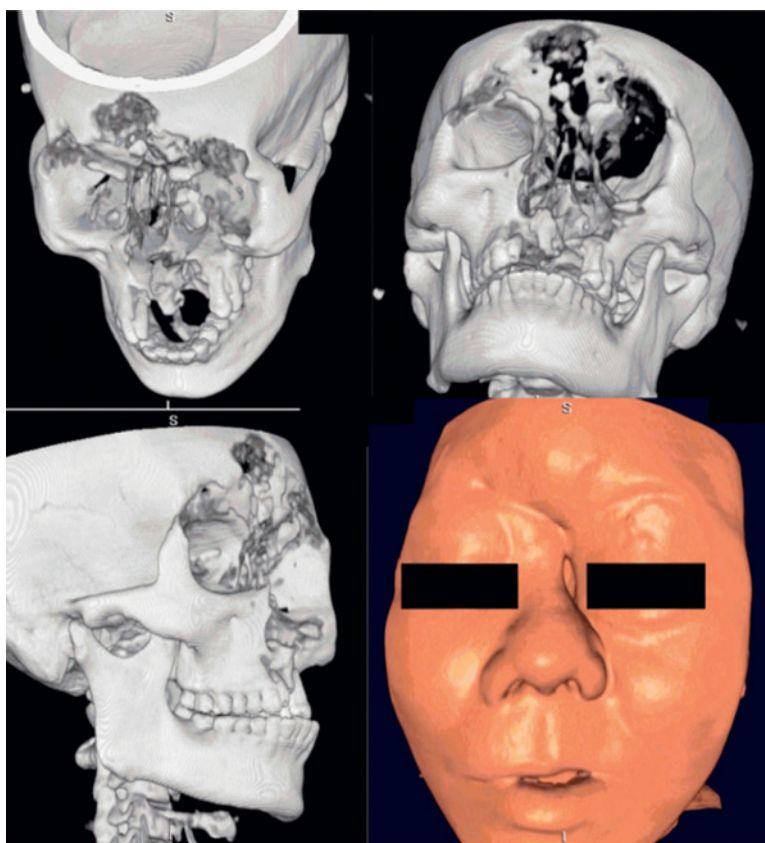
Three-dimensional computed tomography renderings of the same patient as in Figure 4.12 make the destruction of the maxillofacial and frontal regions more obvious. (From Johnson *et al.*, 2007.)
